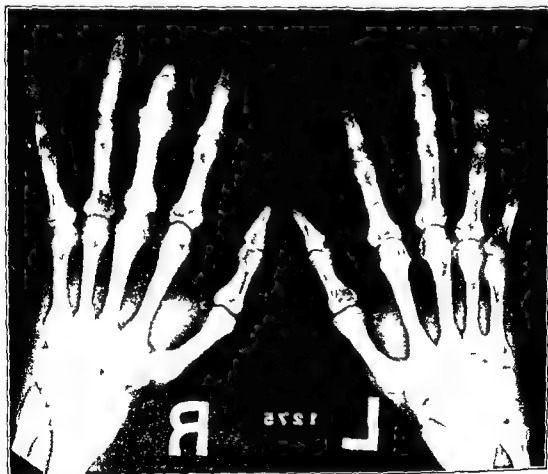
X-ray of the hands in case of chronic gout showing destruction of the metacarpal bone of the little finger and the middle phalangeal joint of the right middle finger.
